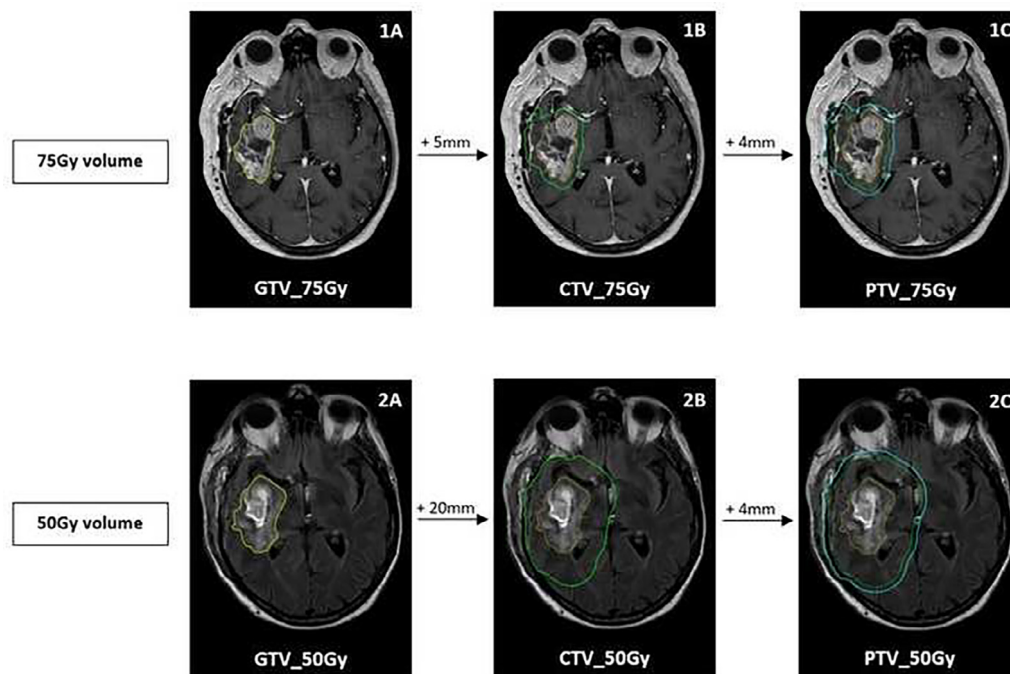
Example of boost volumes (1A–1C) and target volumes (2A–2C). MRI 1A–1C: Contrast enhanced T1 sequence; MRI 2A–2C: Fluid-attenuated inversion recovery sequence. GTV = Gross Tumor Volume; CTV = Clinical Target Volume; PTV = Planning Target Volume.
